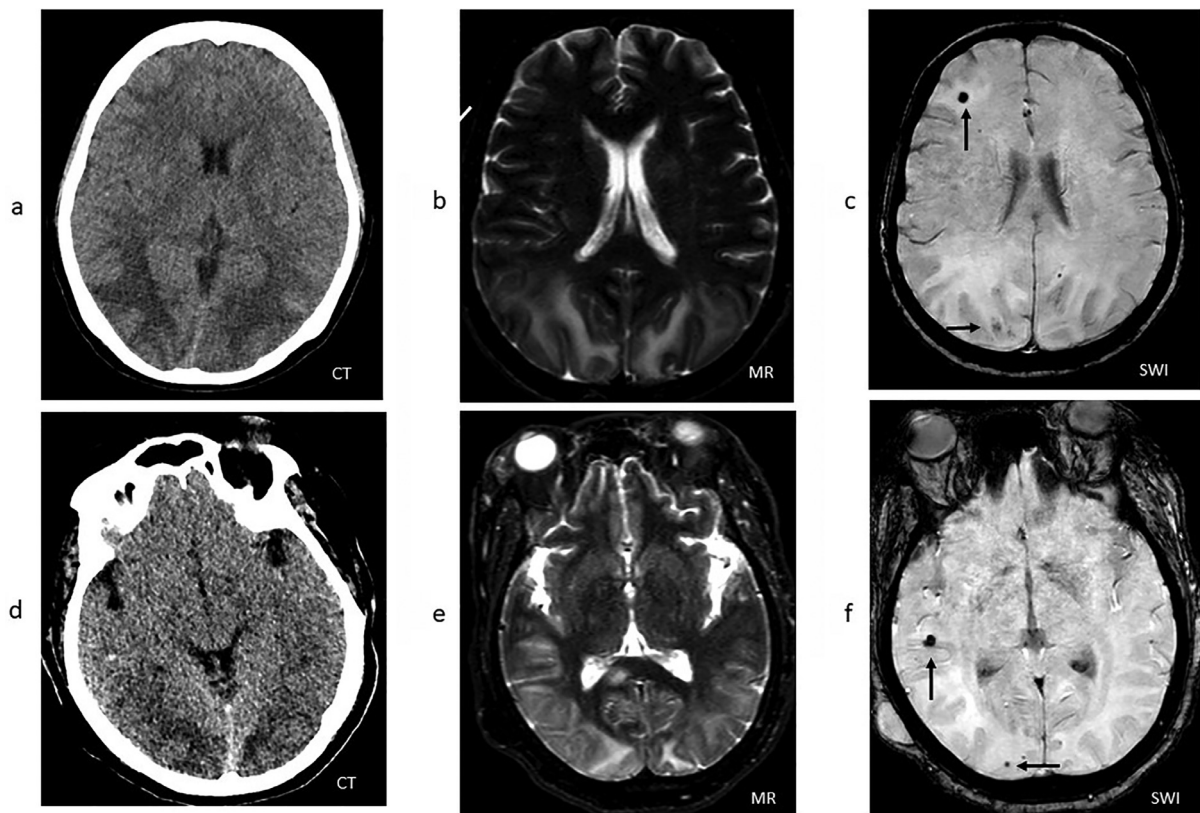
Patient 1: (a) Head CT demonstrating hypodensities involving the subcortical white matter of the bilateral parietal and occipital lobes. (b) Hyperintensities in the same anatomic distribution as the CT on T2-weighted MRI sequences. (c) Multiple foci of susceptibility artifact in the right parietal and frontal lobes (arrows) on susceptibility-weighted MRI sequences. Patient 2: (d) CT hypodensities involving the cortical and subcortical white matter of the bilateral occipital and temporal lobes. (e) Hyperintensities in the same anatomic distribution as the CT on T2-weighted MRI sequences. (f) Multiple foci of susceptibility artifact in the right.
